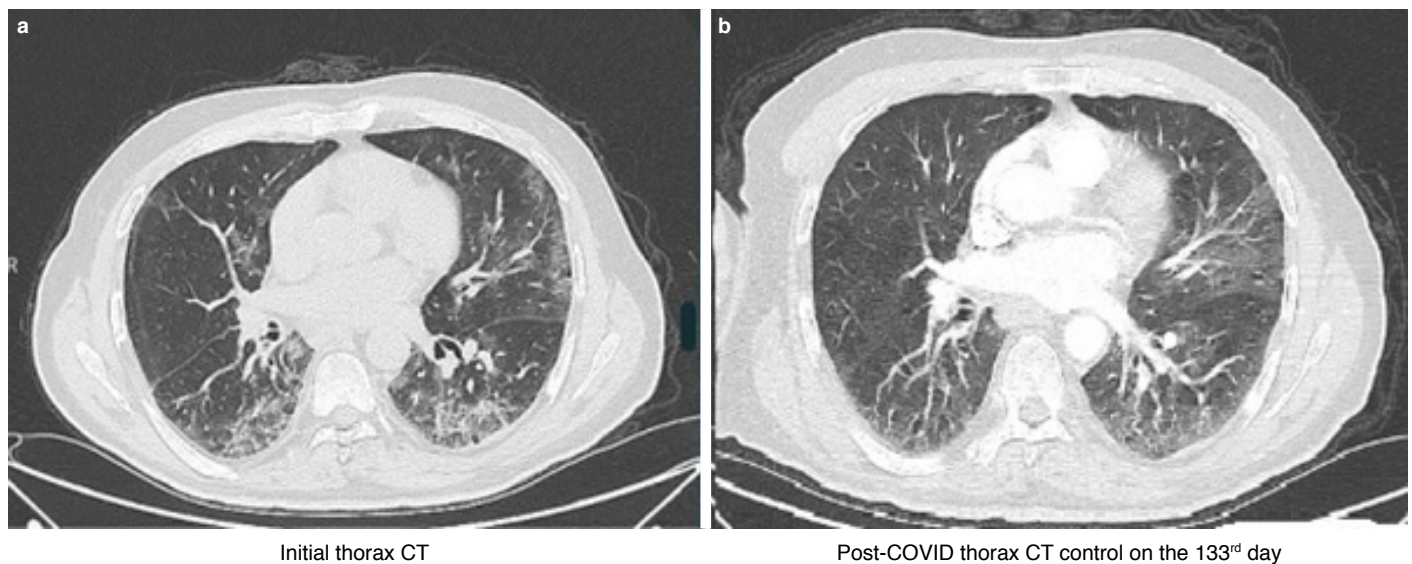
An example of thorax CT for the patients without complete regression showing reticular and ground-glass opacities (a) initial thorax CT and (b) post-COVID thorax CT control on the 133rd day.
